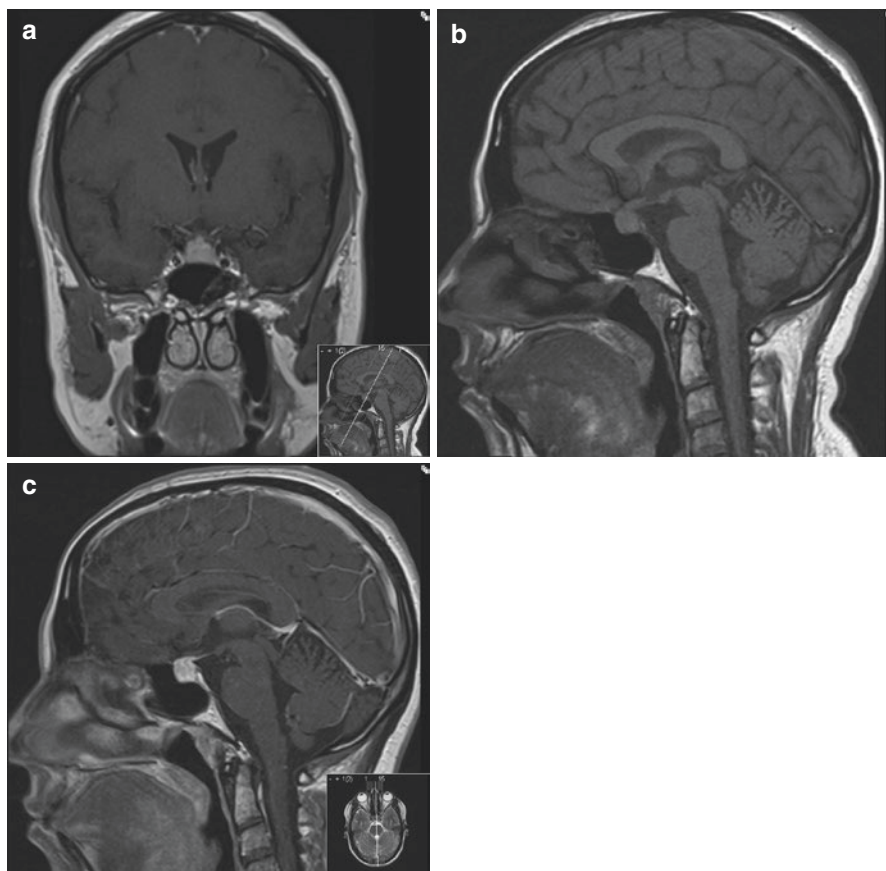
T1 weighted coronal and sagittal MRI (a, b) showing a mass arising from the pituitary fossa which uniformly enhances following administration of contrast (c) and which rises to but does not compress the chiasm. Notice that the normal brightness of the posterior pituitary is absent. The anterior aspect of the pituitary stalk is enlarged and also enhances
